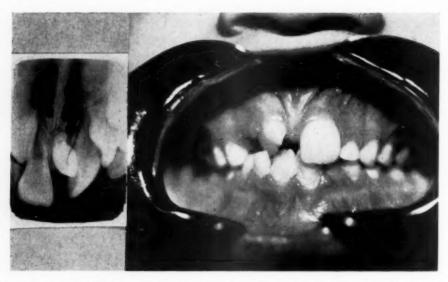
X-ray showing the mesiodens, and photograph of the same girl with the produced anomaly (7 years of age).
